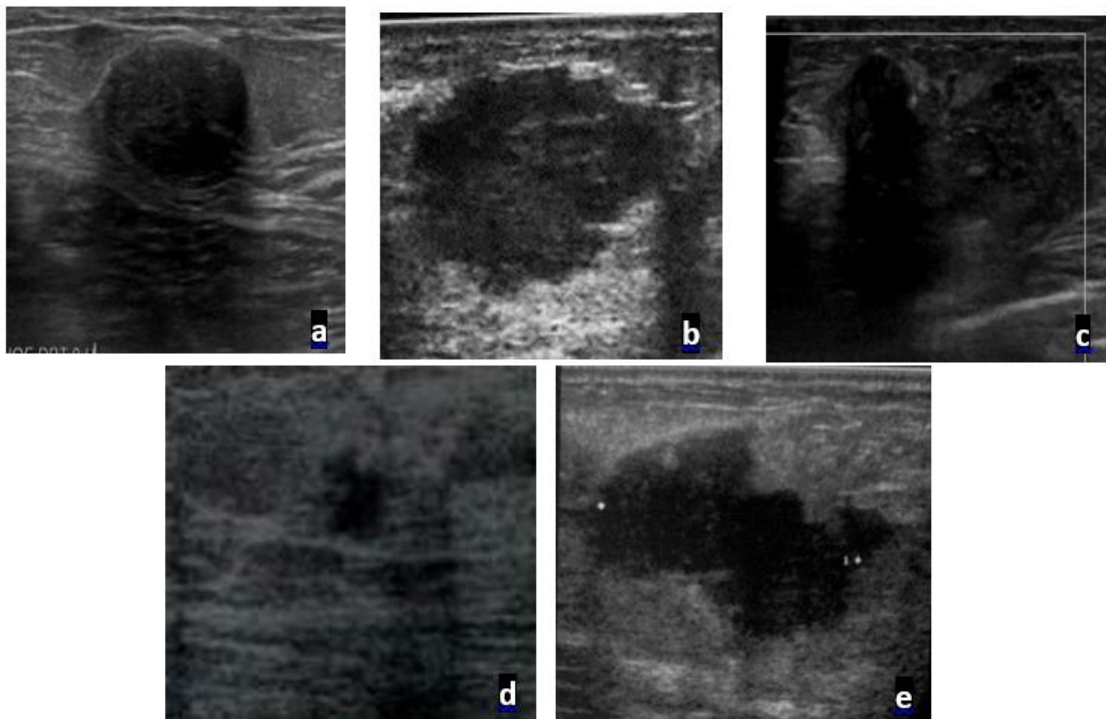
Distribution of masses according to their contours on ultrasound. a: Circumscribed contour, b: Microlobulated contour, c: Indistinct Contour, d: Spiculated contour, e: Angular Contour
